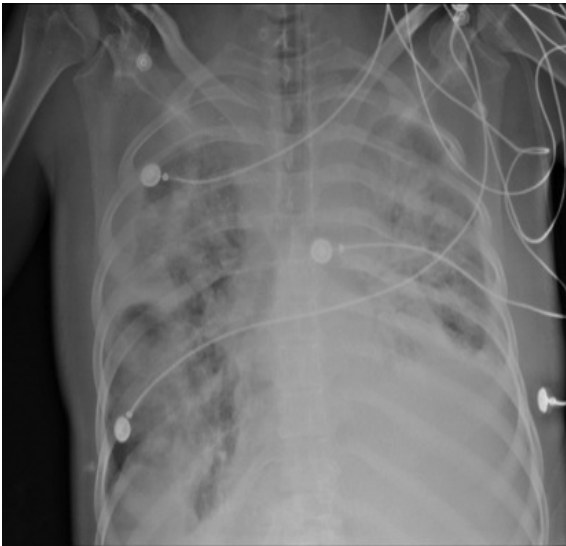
Posteroanterior chest radiograph on hospital day 20. Widespread infiltration present in both lungs.
